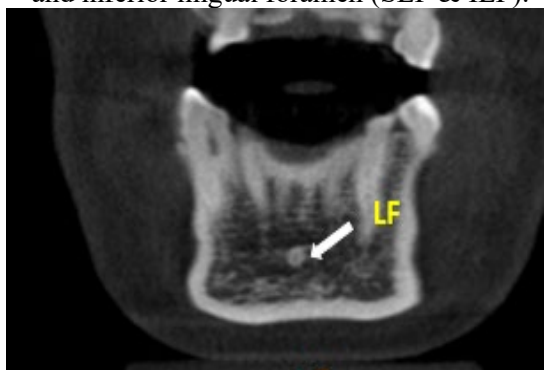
Sagittal plane of CBCT showed lingual foramen (LF).
